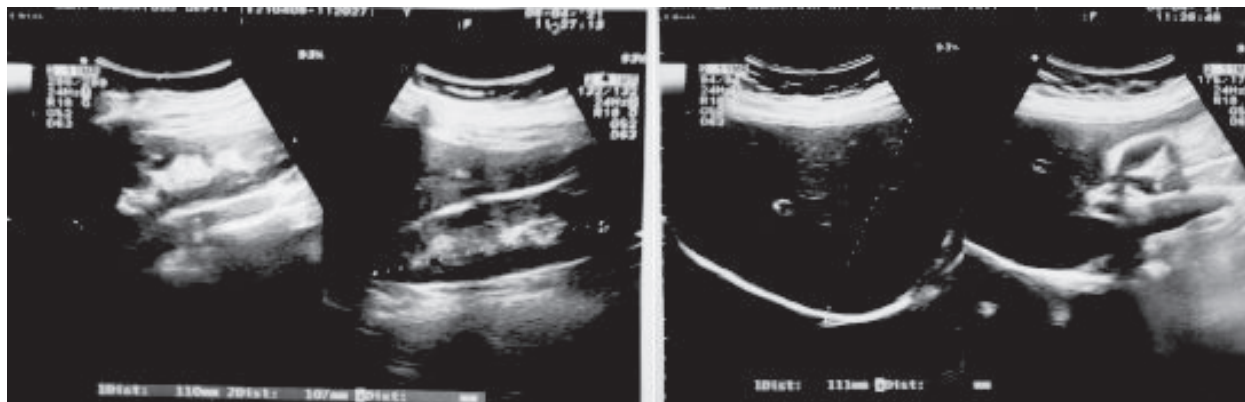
Ultrasonogram of whole abdomen on 08th April 2021
